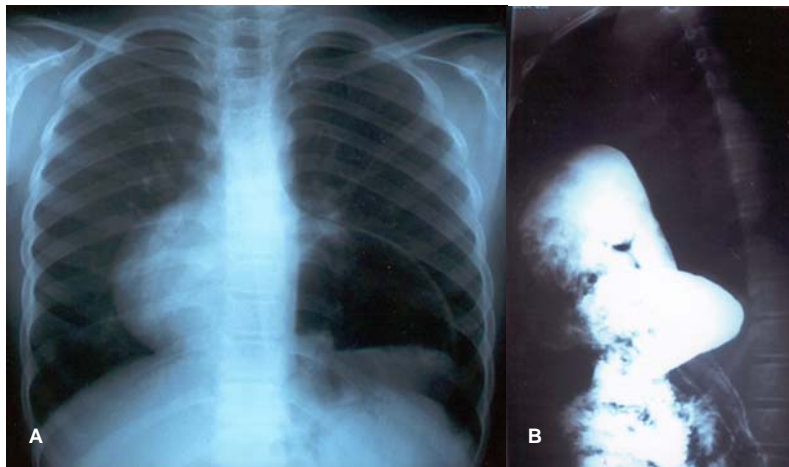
Anteroposterior chest radiograph showing dextrocardia and hiatal hernia (paraesophageal) (A) and Lateral view of barium filled esophagus and stomach in the thorax (B).
